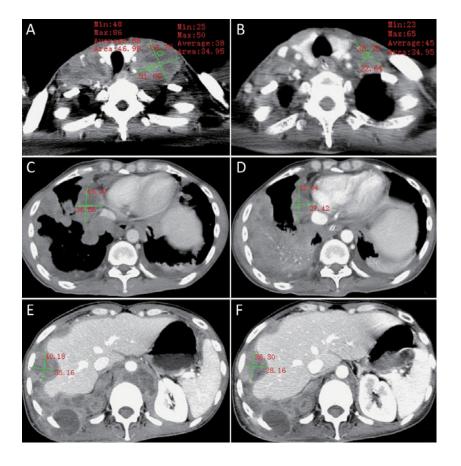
CT images before and after the treatment of CPT-11 [A, C, E, on d (-3); B, D, F, on d (+21)]. A, B: Tumor in the cervical lymph nodes; C, D: Tumor in thorax; E, F: Tumor in epigastrium.
